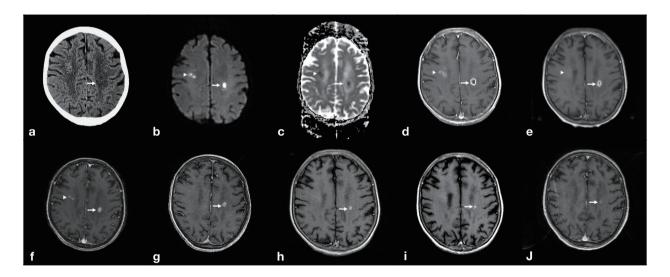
1a: Brain computed tomography. 1b: Magnetic resonance imaging diffusion-weighted images (DWI) and corresponding apparent diffusion coefficient (ADC) maps (1c) as well as T1-weighted Gd-contrast enhancement (1d-1J). Figure 1a, at the time of admission, showing a hypointense lesion (white arrow) in the left frontal lobe. Figures 1b, 1c and 1d, captured at the time of admission, showing bilateral frontal lobe cystic lesions with ring enhancement. Figures 1e-1i, captured at the 2nd, 4th, 6th, 8th, and 10th weeks, respectively, showing a gradual regression of the brain abscesses. Figure 1j, captured at 22 months after treatment, showing a mild residual enhanced lesion.
